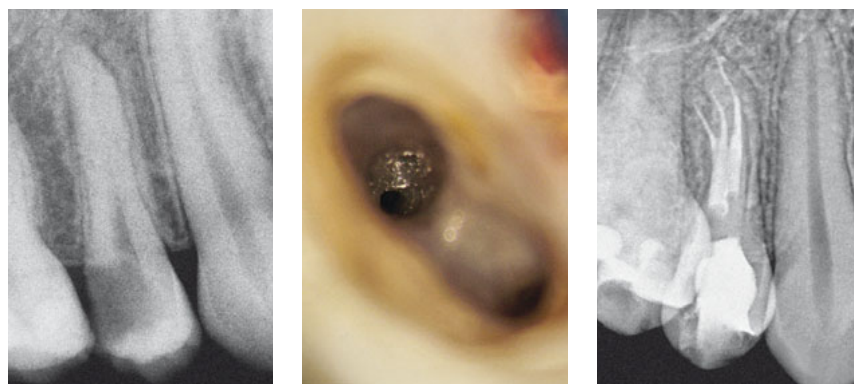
The diagnostic radiograph of the maxillary premolar reveals a large centred root canal that abruptly 'disappears' in the middle third of the root. During the intracanal inspection, a ramification of the main canal was obvious in the depth of the buccal root. The final radiograph reveals the complex anatomy of the root canal system.
